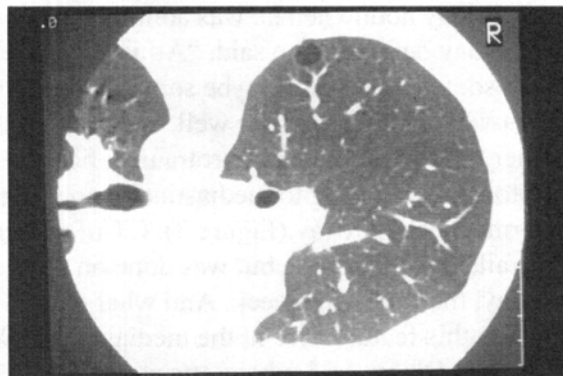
Chest CT of the same diver (Case 4).
